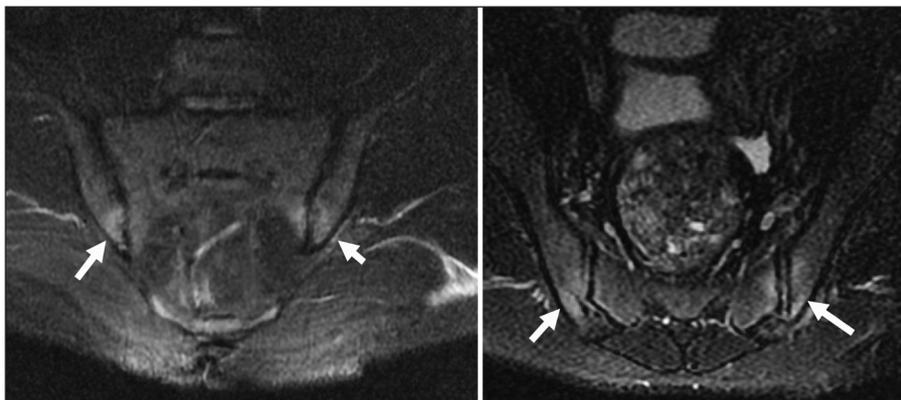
Sacroiliac magnetic resonance images: Bone marrow edema is observed on the sacral and iliac surfaces facing the sacroiliac joints.
